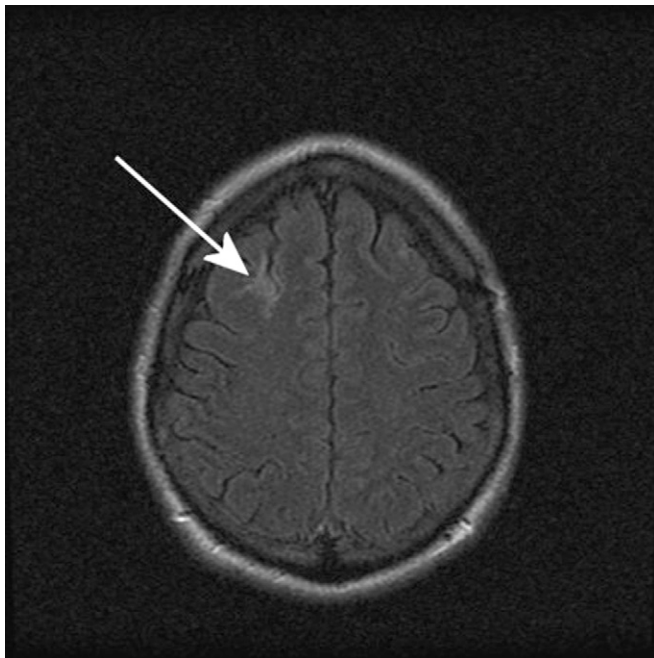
Subsequent FLAIR MRI image completed at home station demonstrating a persistent lesion along the right frontal sulcus consistent with microvascular ischemia secondary to DCS (solid arrow).
